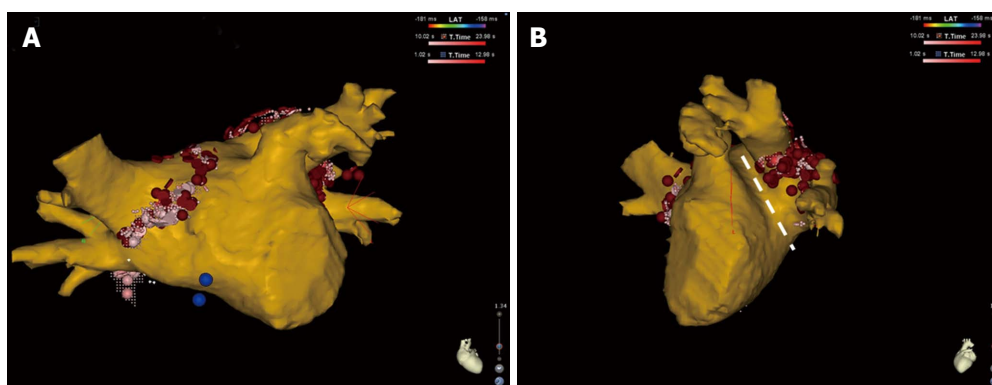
Antero-posterior (A) and left lateral (B) view of three-dimensional reconstruction of the left atrium and pulmonary veins after merging the cardiac computed tomography with the electroanatomical map created with the Carto 3 system (Biosense Webster, Inc., Diamond Bar, CA, United States). Note the ablation tags (red dots) placed around the pulmonary vein ostia on the computed tomography reconstruction. In the left lateral view, the narrow ridge between the left-sided pulmonary veins and the left atrial appendage can be appreciated (white dashed line).
